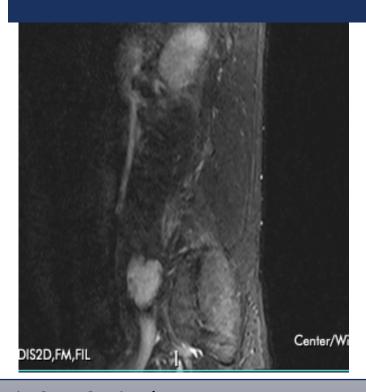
Sagittal post-contrast T1 MRI image showing non-enhancing hematoma extending longitudinally along the left lower psoas muscle
